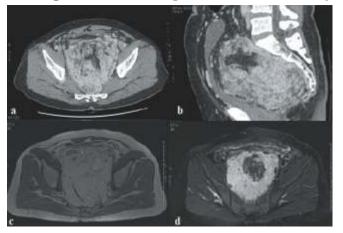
CECT axial and sagittal images: Heterogeneously enhancing mass in pelvis with fatty areas (a & b). Pre and post contrast MRI Fat Sat axial images showing heterogeously enhancing mass in pelvis with fat suppression areas c & d)
